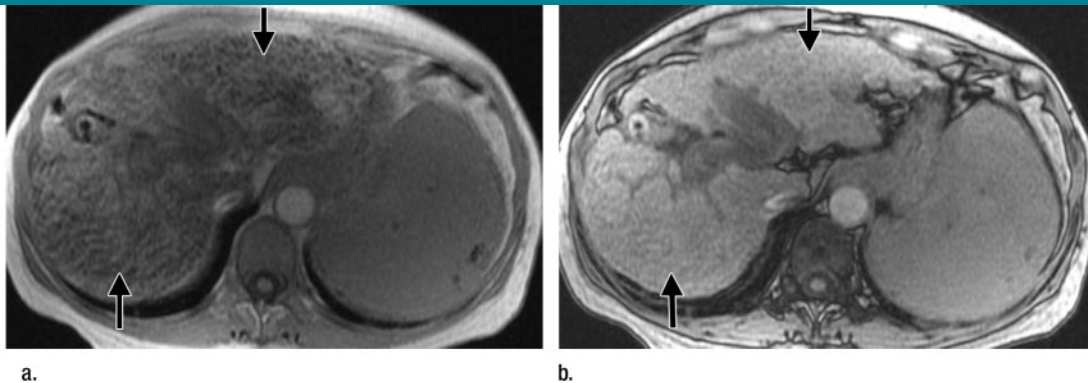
Transverse T1-weighted MR images in 50-year-old woman with cirrhosis secondary to autoimmune hepatitis. There is marked signal intensity loss throughout the hepatic parenchyma (arrows) on the (a) in-phase image (repetition time msec/echo time msec, 170/4.4; 70° flip angle) in comparison with the (b) opposed-phase image (170/2.2, 70° flip angle), secondary to the presence of siderotic regenerative or dysplastic nodules.
